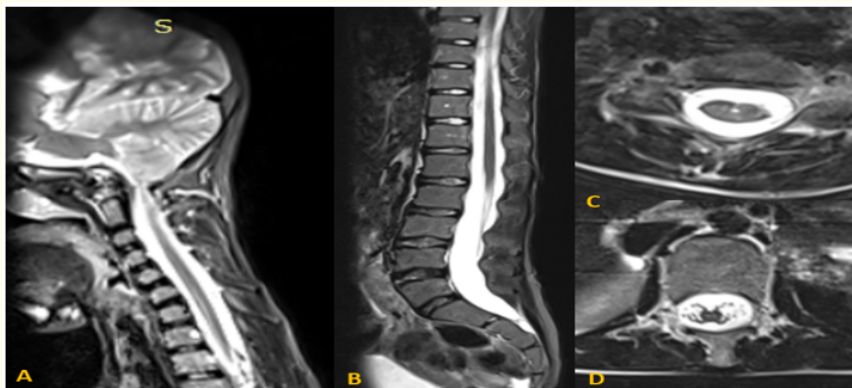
Spinal MRI findings in a 9-year-old girl with Marfan syndrome. (A) Sagittal T2-weighted image of the cervical spine showing basilar impression at the craniovertebral junction. (B) Sagittal T2-weighted image of the lumbar spine demonstrating diffuse enlargement of the dural sac, predominantly involving the lower lumbar and lumbosacral levels, consistent with dural ectasia, without significant posterior vertebral scalloping. (C, D) Axial T2-weighted images at different spinal levels showing enlargement of the dural sac and increased perimedullary/periradicular cerebrospinal fluid spaces, without associated dural diverticula.
